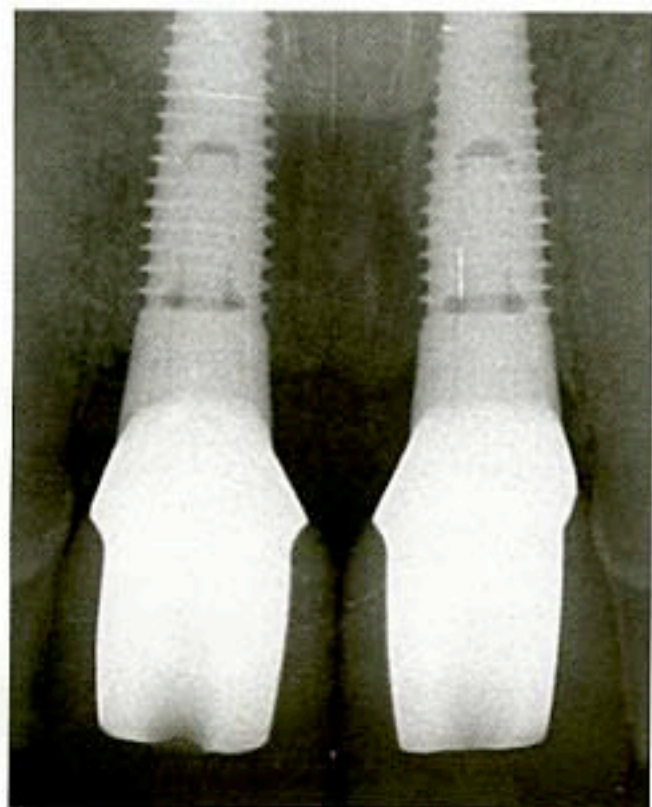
Radiograph of two adjacent scalloped implants at  $T_1$ .
